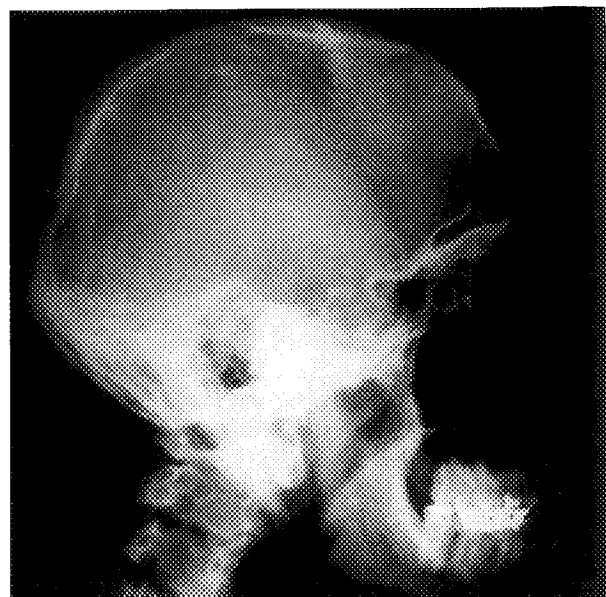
Lateral radiograph of the skull showing eroded floor of sella turcica.
